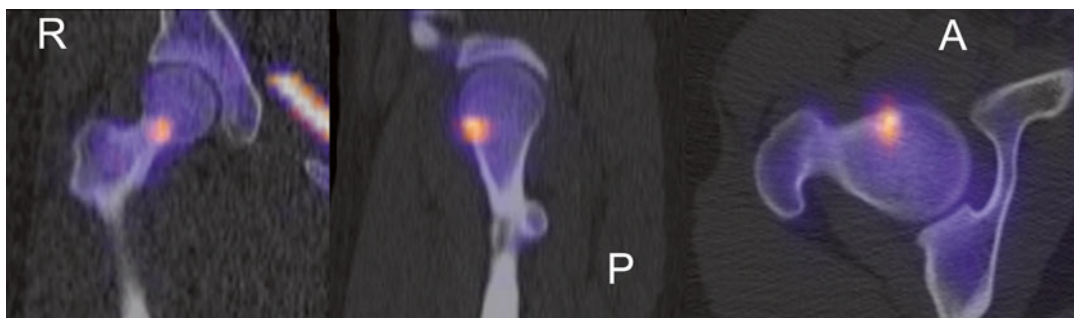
Osteoid osteoma of the right femoral neck. ^{99m}Tc -MDP SPECT fused to a CT helps with the anatomic localization of the lesion
